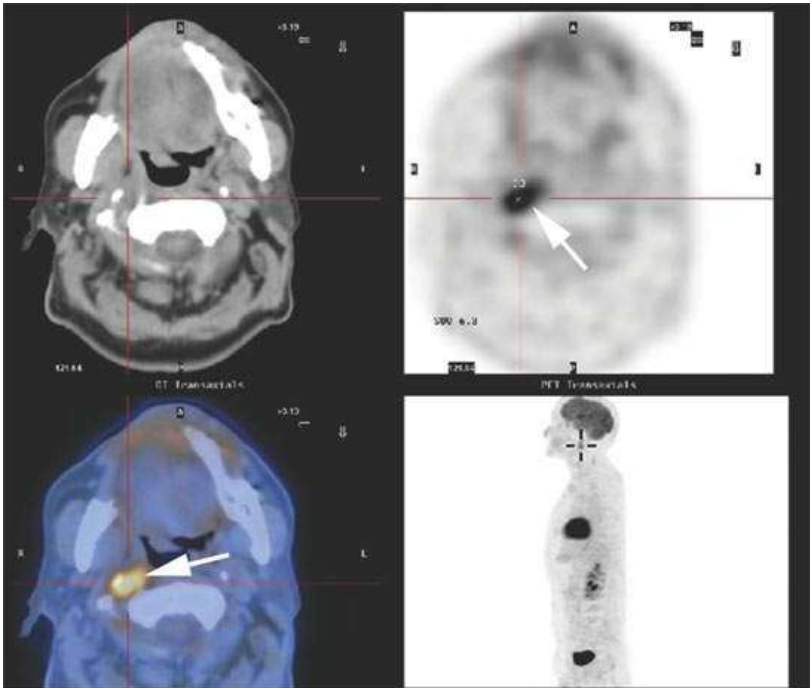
A patient treated for head and neck cancer developed right suboccipital headaches about 1 year after treatment. Fluorine-18 2-fluoro-2-deoxy-D-glucose positron emission tomography (FDG-PET) study showed the failure to be in the retropharyngeal node on the right (*arrow*).
